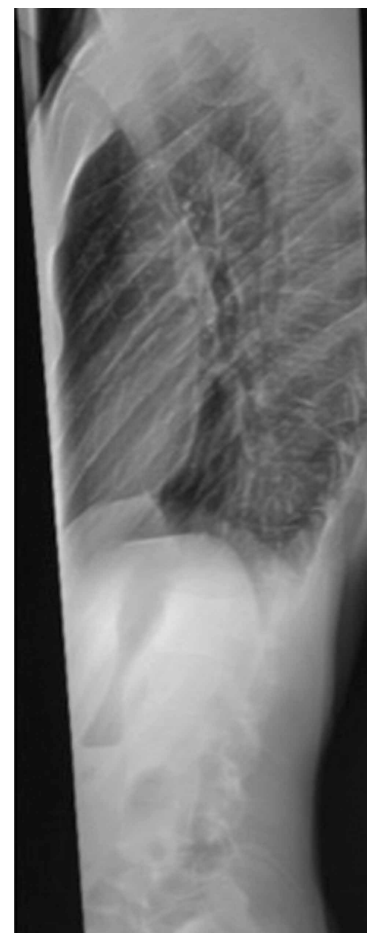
Preoperative lateral radiograph.
